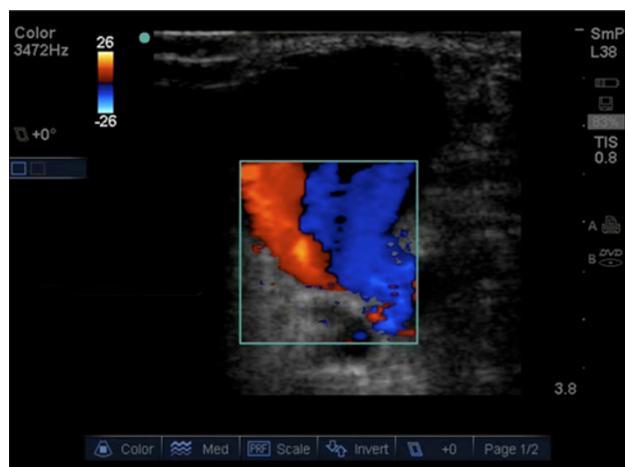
Ultrasound image of the “swirl” or “yin-yang” sign
